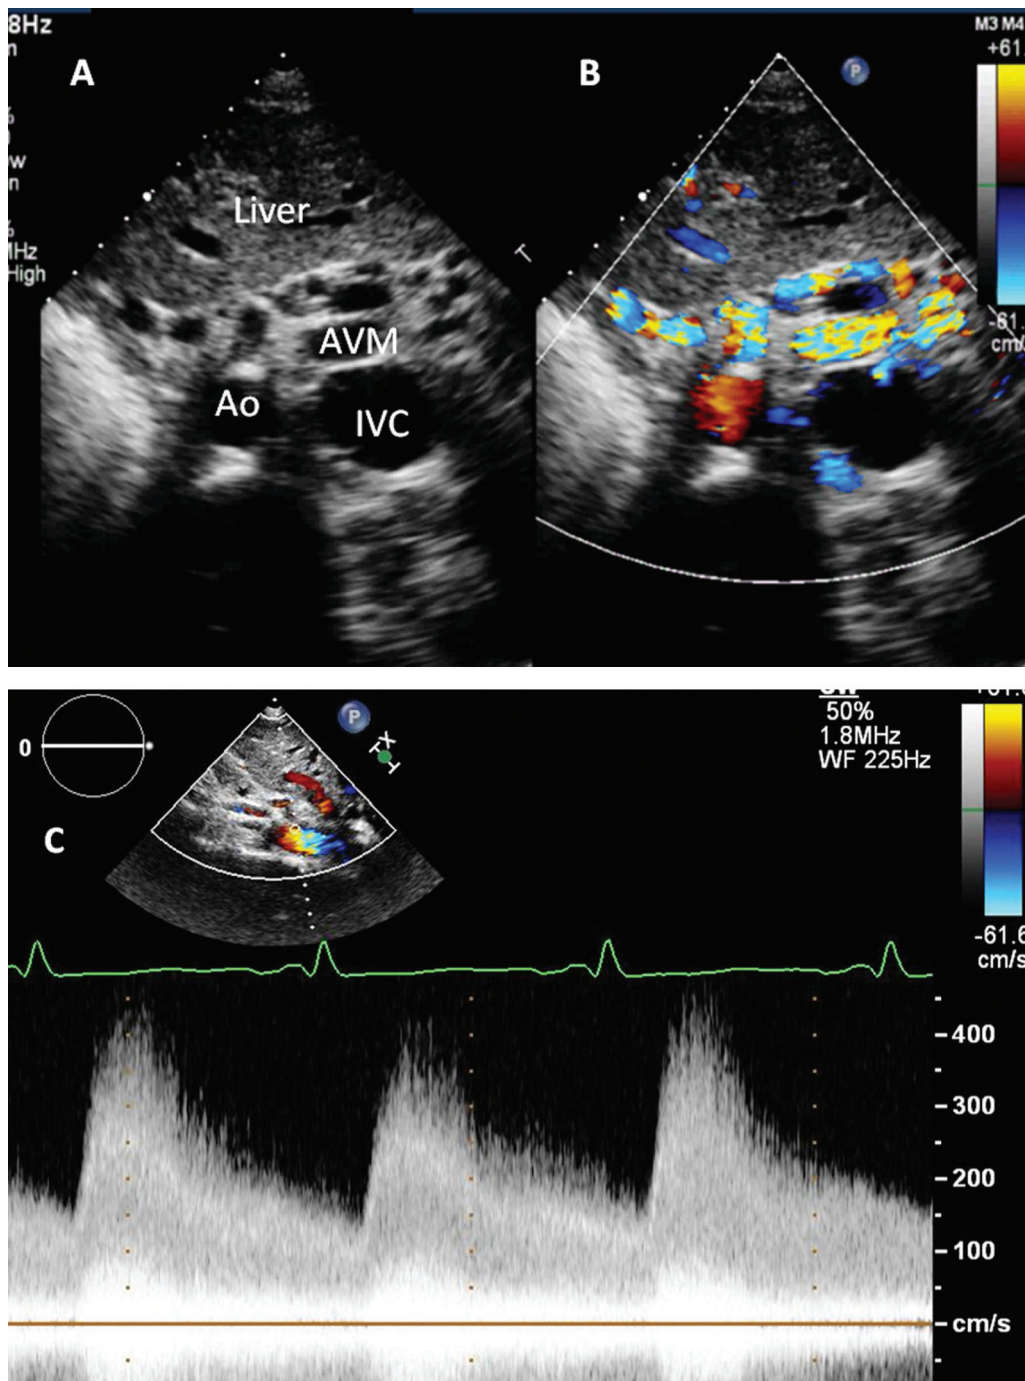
Liver ultrasound demonstrating multiple, large arteriovenous fistulae (A and B) with grossly increased flow in the celiac axis (C).
